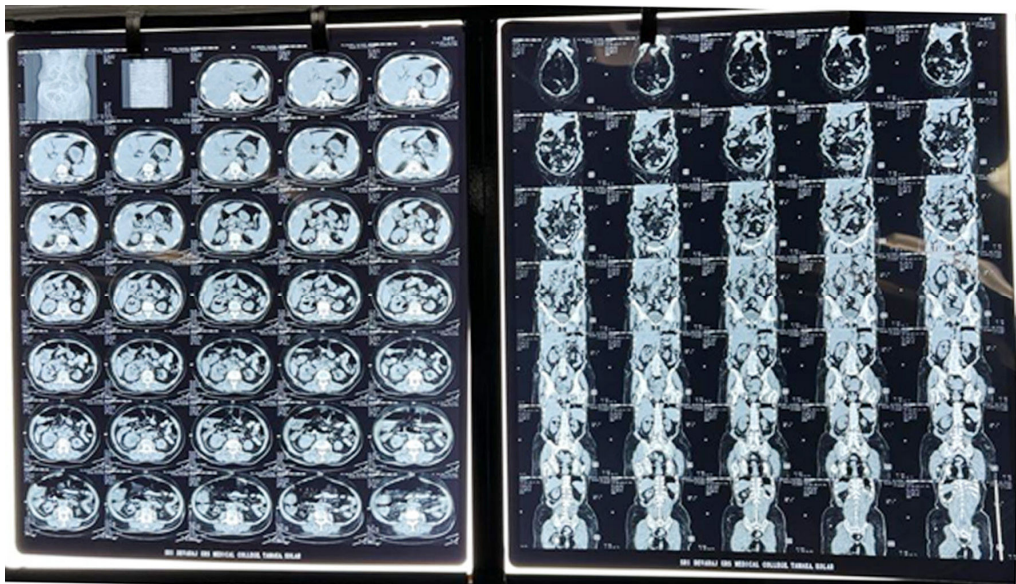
CT Showing the Perinephric Abscess and Lobar Pneumonia
